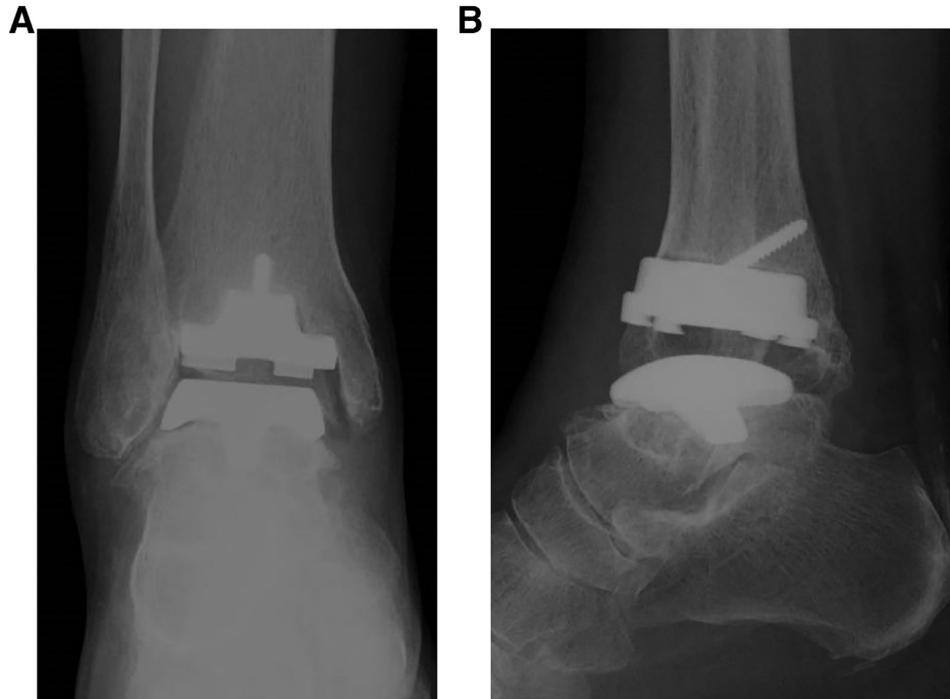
Postoperative radiographs after primary total ankle arthroplasty using the TNK ankle. (A) Anteroposterior; (B) lateral.
